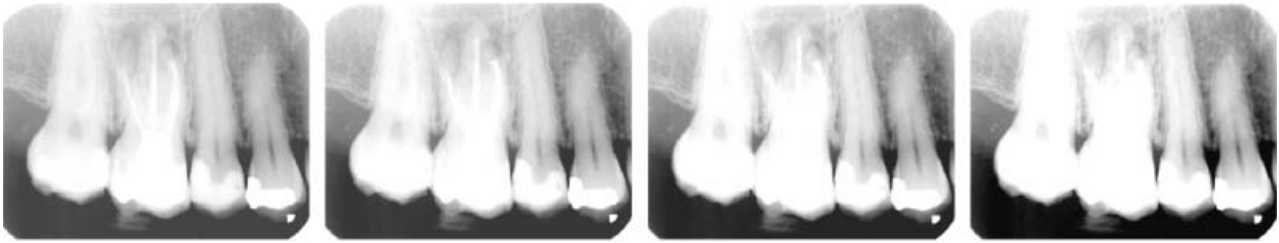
Increasing contrast only in a radiograph that is too light to start with usually does not improve its diagnostic value.
